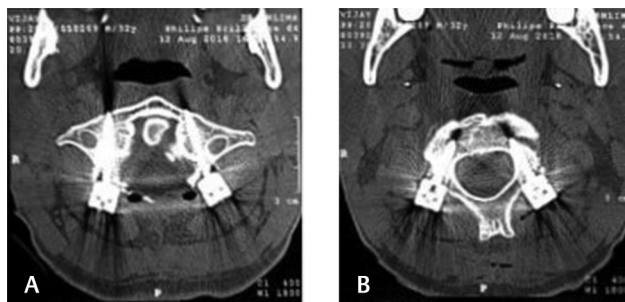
Postoperative axial view of C1 lateral mass screw (A) and C2 pedicle screw (B) fixation on computed tomography (CT) scan.
